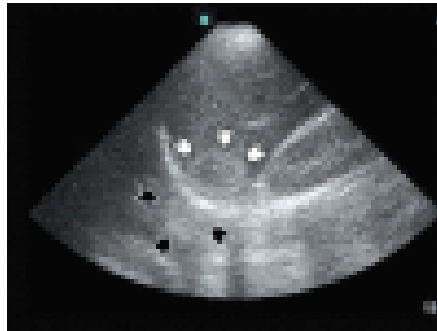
Ultrasound image, transabdominal showing
